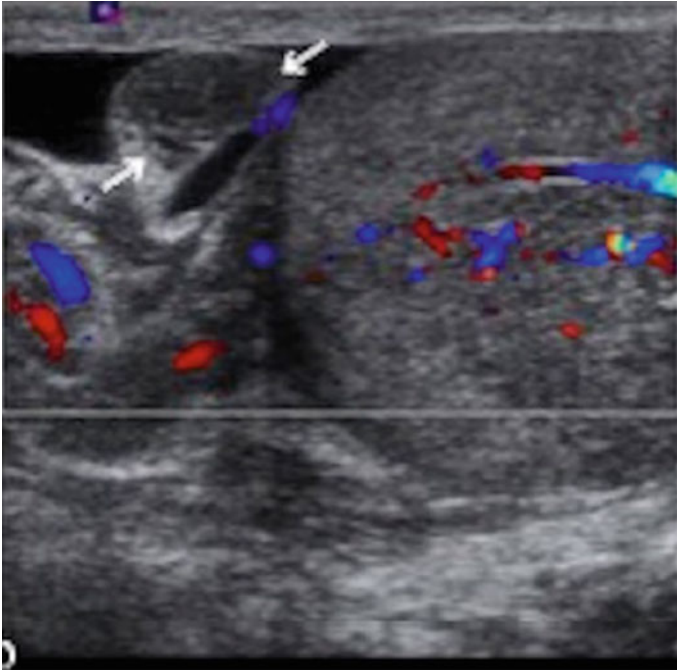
Appendiceal torsion on doppler US, with an enlarged and avascularized mass (arrows)²⁰
